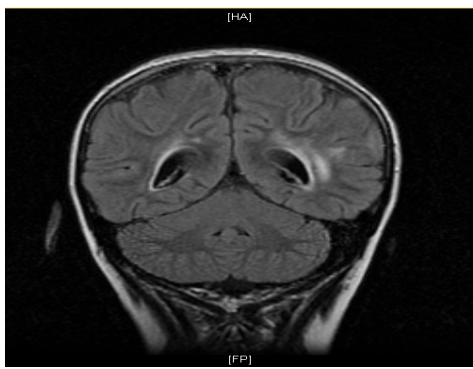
(b): MRI of the Brain FLAIR Sequence Coronal View Showing Hyperintensities in the Cerebral White Matter
